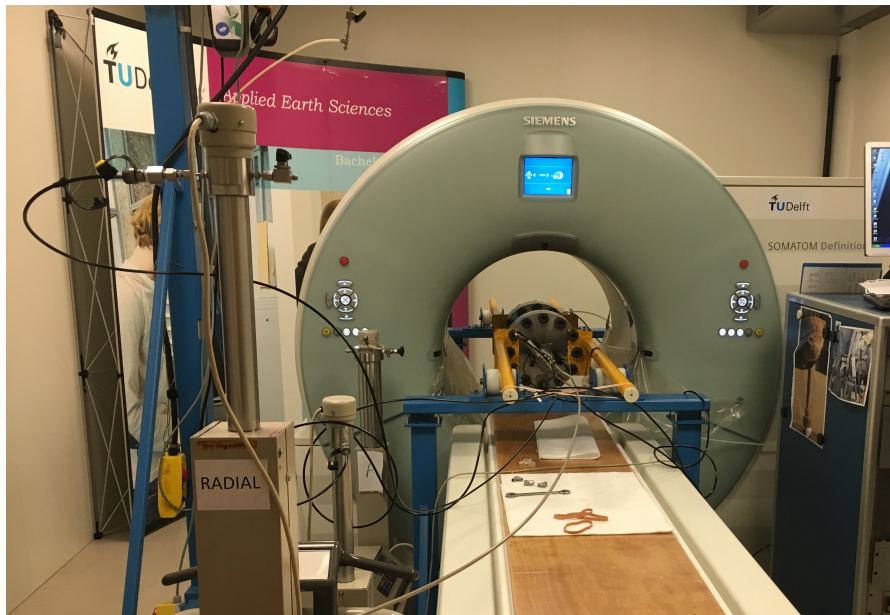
CT cell in CT scanner
